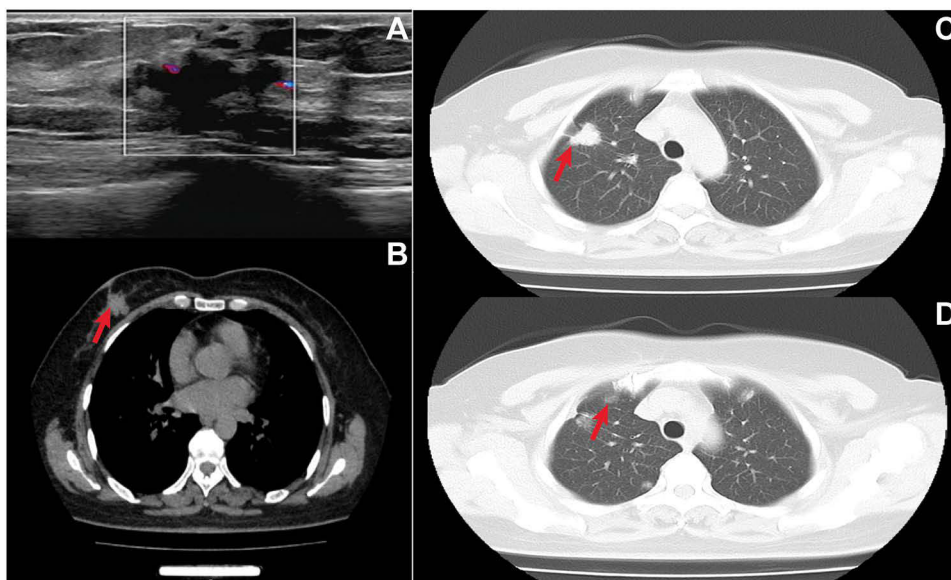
Pre-diagnostic imaging findings of the patient. (A) Breast ultrasound showing a breast mass (breast mass is indicated by the white box). (B–D) Chest computed tomography (CT) images, red arrows indicate the breast mass (B) and lung nodules (C and D).
